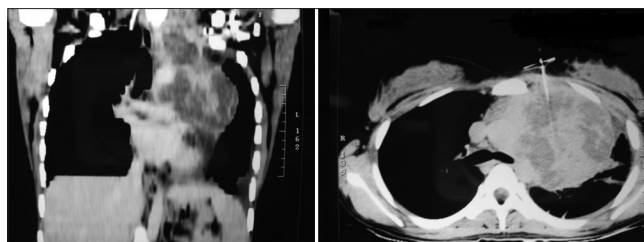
Contrast enhanced computed tomography thorax showing a huge, heterogeneous anterior mediastinal mass extending to neck through the thoracic inlet
